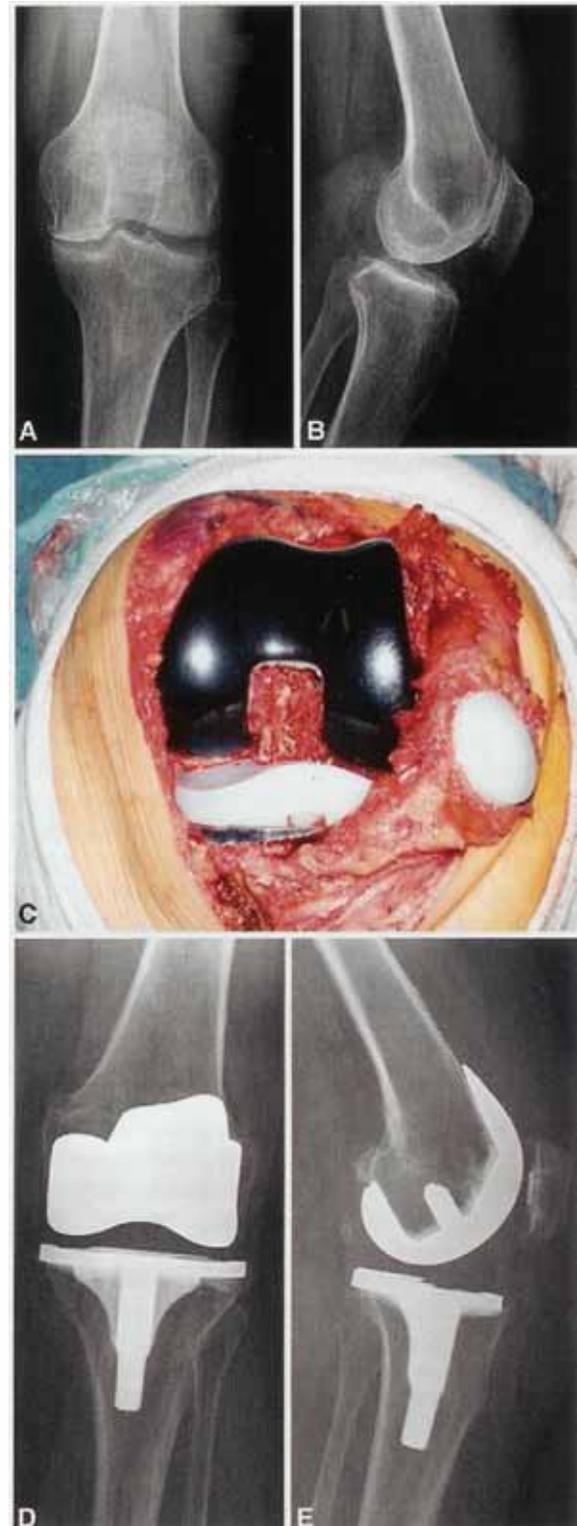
These (A) anteroposterior and (B) lateral radiographs show the varus osteoarthritis in the left knee of a 64-year-old man with a body mass index 22.4 kg/m<sup>2</sup>. (C) An intraoperative photograph shows the implant with the oxidized Zr femoral component. (D) Anteroposterior and (E) lateral radiographs shows the cruciate retaining Genesis II implant with an Oxinium femoral component and patellar resurfacing at the 6-year follow-up.
